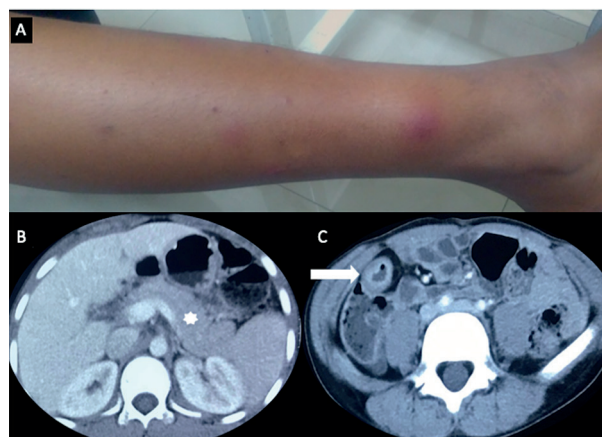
A) Skin lesions consistent with panniculitis B) CT Showing bulky pancreas C) Mural thickening and stratification in terminal ileum.
